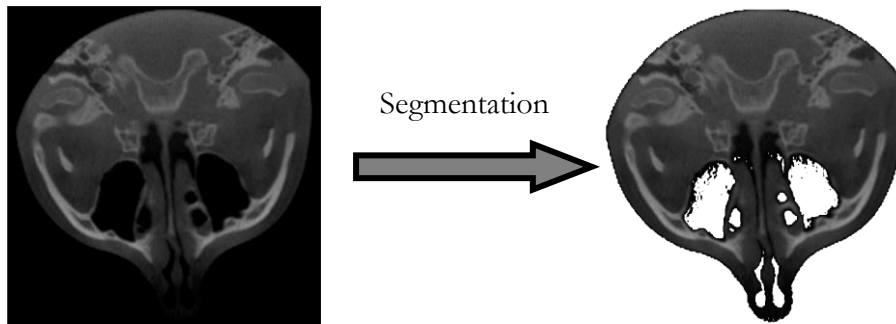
Example of a segmentation of CT scan of the head.
